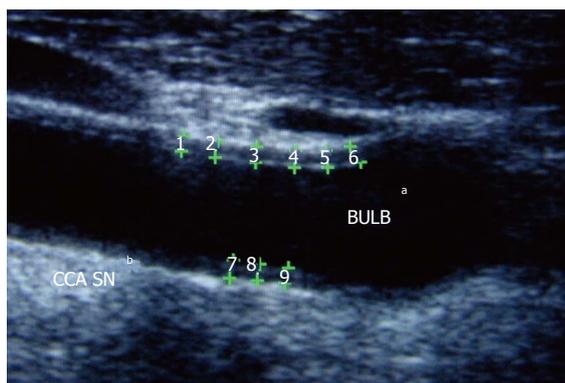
B-mode ultrasound measurement of carotid intima media thickness in patient with Rheumatoid Arthritis. ^aBULB: Carotid bulb; ^bCCA SN: Left common carotid artery.
